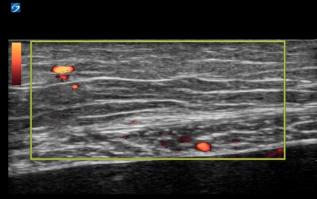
Identification of inferior epigastric artery using power Doppler. Transverse view of the abdominal wall showing blood flow indicated by Power Doppler (inferior epigastric artery). An additional vessel is also seen on screen left in the near field. Ensure Doppler box (yellow box) captures the entire abdominal wall
